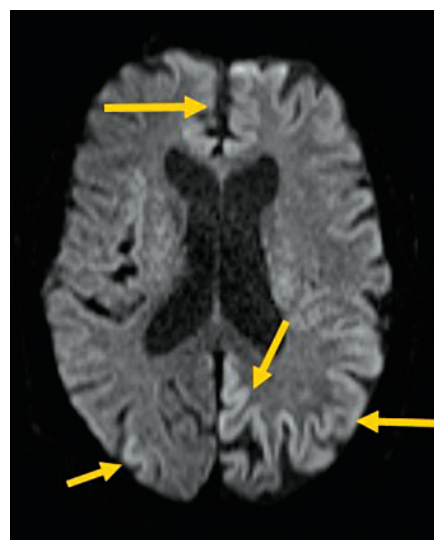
MRI of patient 4 – DWI-MRI – hyperintensities more pronounced on the left, fronto-mesially (yellow arrows), with mild diffuse atrophy, with slightly enlarged ventricles
